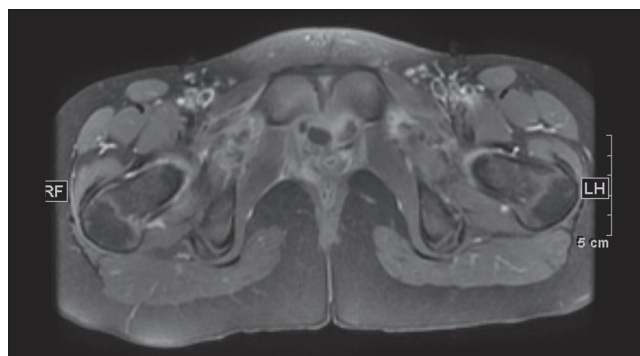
Magnetic resonance image of pelvis and upper thighs (AX T1 FS with gadolinium) with special attention to symphysis pubis abscess and continued involvement of obturator externus
